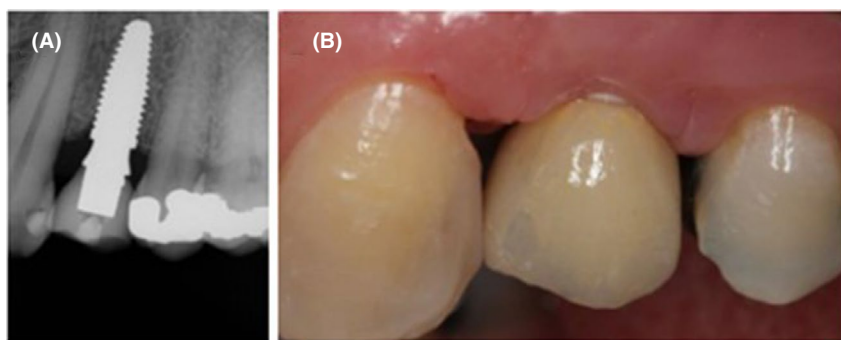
(A–B) Patient 2: Periapical x-ray and lateral photograph of final crown of implant 24, 3 months after surgery
